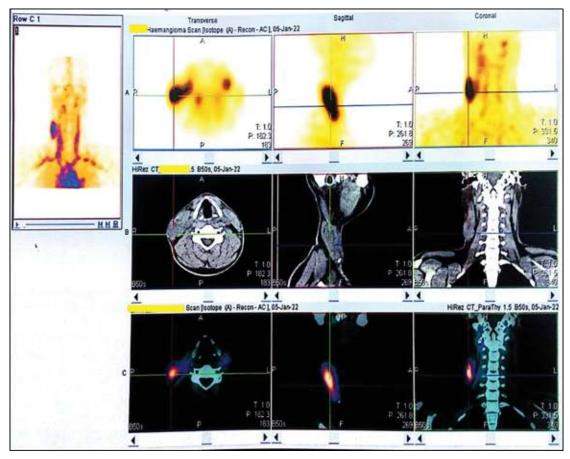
SPECT-CT fusion: CT scan of the neck revealed thickened belly of the right sternocleidomastoid muscle (\sim 2.4 cm thick), showing an elongated hypodense lesion with lobulated appearance (dimensions: \sim 5.6 x 2.2 x 2.3 cm) on its lateral aspect and multiple tiny calcifications below that; while the left sternocleidomastoid muscle appeared normal. In fused images the focal area of intense tracer activity corresponds to the hypodense lesion in the belly of right sternocleidomastoid muscle.
